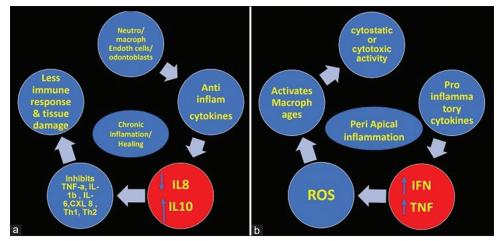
(a and b) Cytokines as diagnostic markers in chronic inflammation/healing and periapical inflammation
